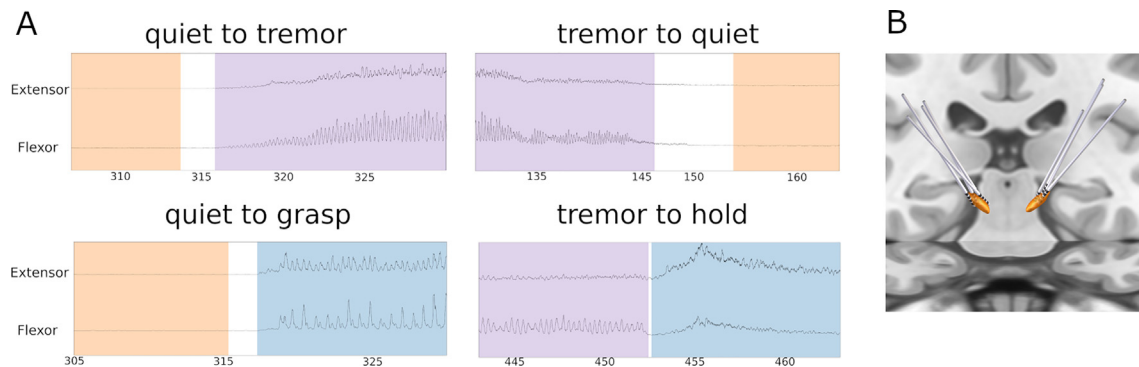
Data labelling and electrode placement. A. Labeling of behavioral states in forearm EMG, state transition examples. B. Localization of deep brain stimulation (DBS) electrodes for four out of six patients. For two other patients (S02 and S03) the CT image quality was not sufficient for localization.
